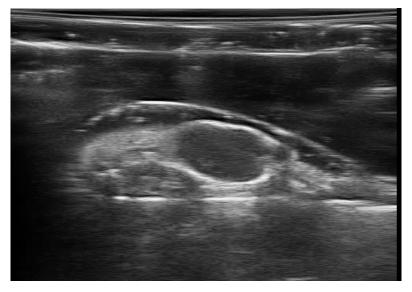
Tumor imaging from Ultrasonix SonixMDP
